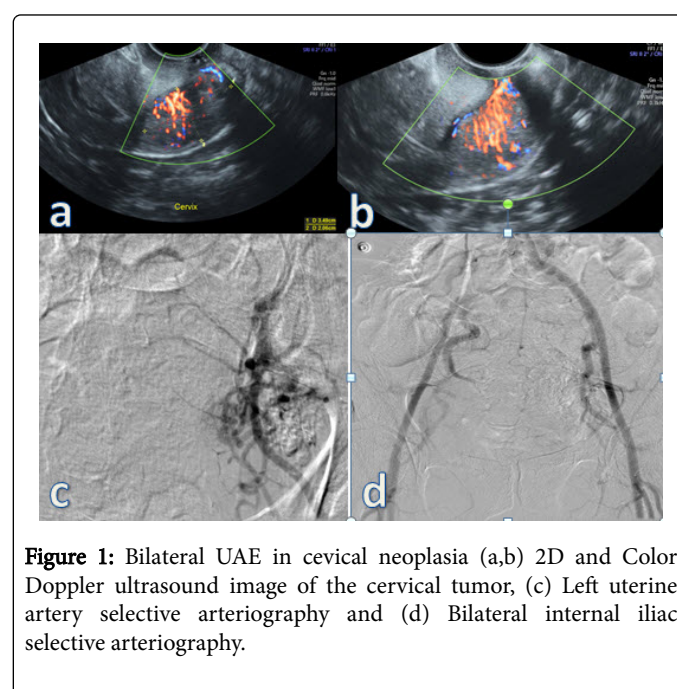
Bilateral UAE in cervical neoplasia (a,b) 2D and Color Doppler ultrasound image of the cervical tumor, (c) Left uterine artery selective arteriography and (d) Bilateral internal iliac selective arteriography.
